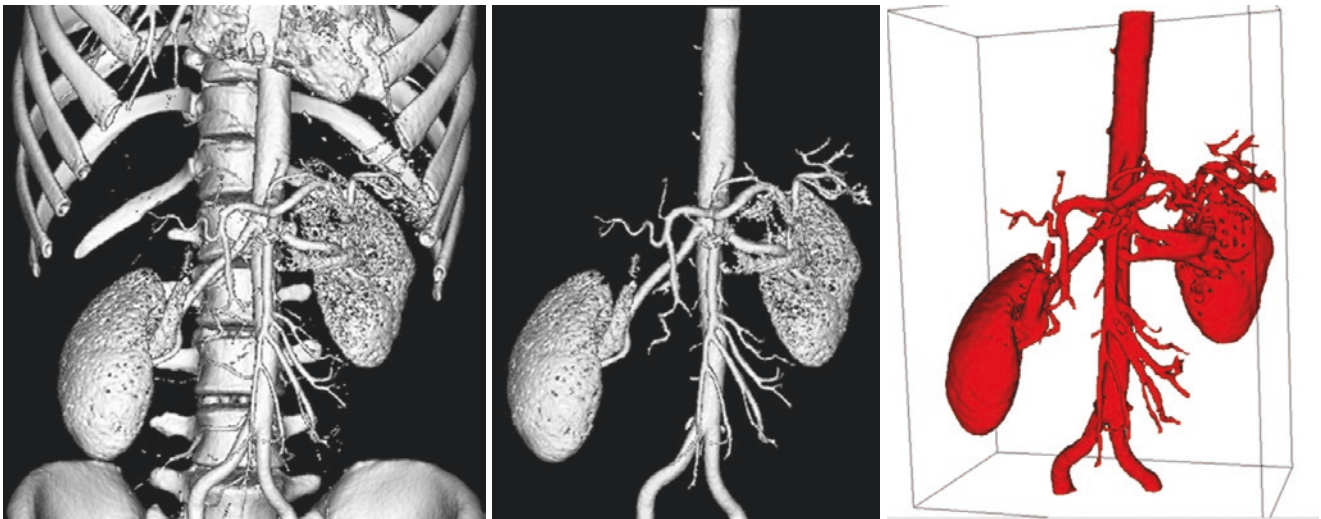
Image segmentation of contrast-enhanced abdominal aorta and its arterial branches using CT number thresholding technique. Minimum CT attenuation of 150 HU is applied to the volume data to segment the contrast-enhanced vessels and kidneys from the surrounding soft tissue structures. Bones are still kept in the initial segmented
